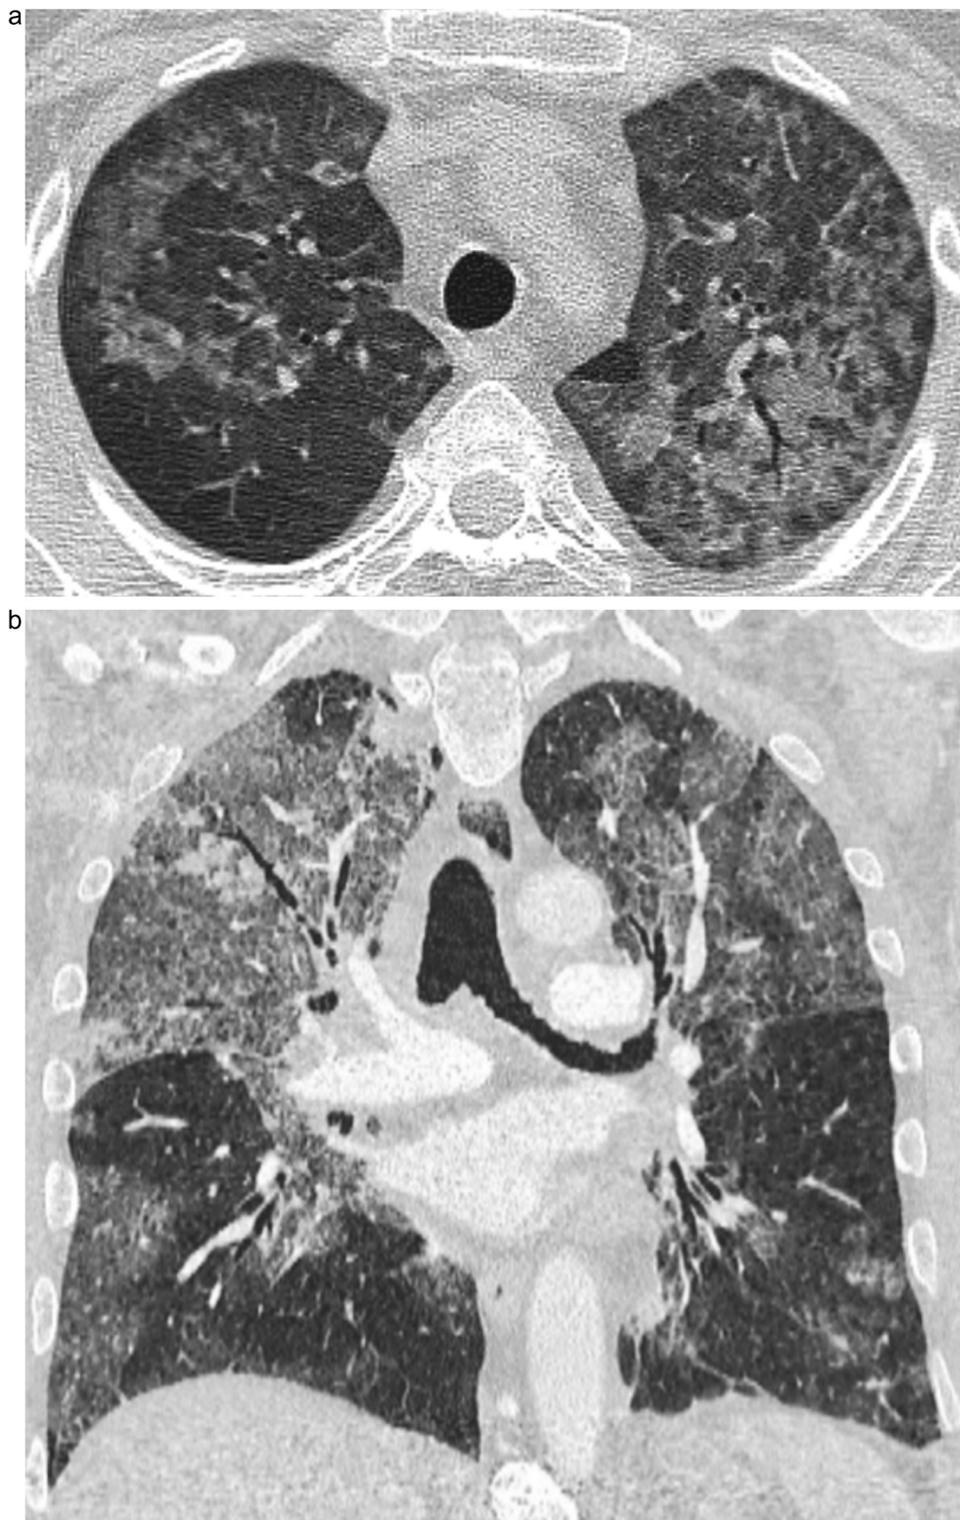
Typical HRCT findings of *Pneumocystis jirovecii* pneumonia (PJP).
